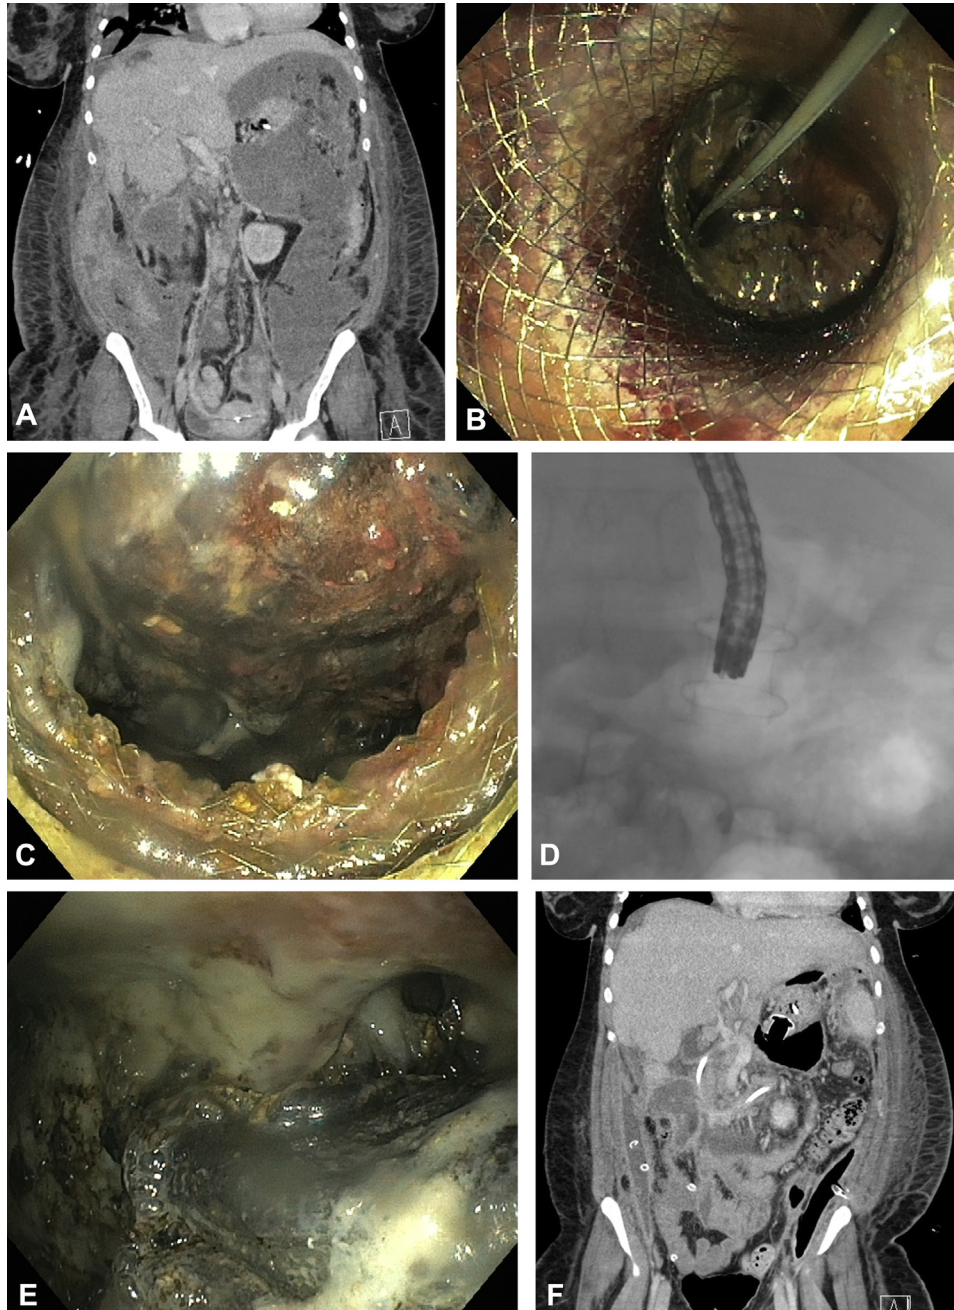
A, Contrast-enhanced abdominal CT image showing a mature, large, left-sided collection. B, Fully deployed 20-mm LAMS across cystgastrostomy, with visible necrotic debris in the cavity. C, Endoscopic appearance of a fully expanded 20-mm LAMS 2 weeks after deployment, with significant necrosis seen in the cavity. D, Fluoroscopic image of a transgastrically placed 20-mm LAMS, with a therapeutic upper endoscope passing through the stent into the necrotic cavity. E, Endoscopic appearance of cavity during initial necrosectomy. F, Follow-up contrast-enhanced abdominal CT scan showing improvement in size of left-sided collection. *LAMS*, lumen-apposing metal stent.
